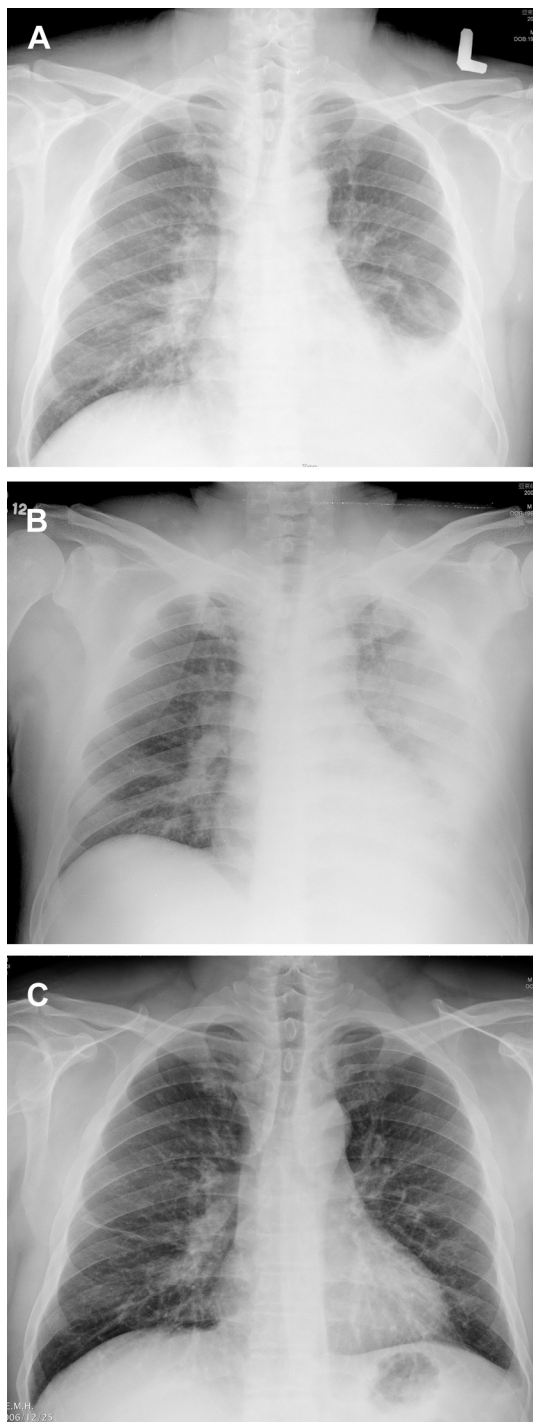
(A) Chest plain film in May 2006 shows haziness in the left lower lung field, increased infiltrates in the right lower lung field, near the right hilum, and suspicious upper mediastinal widening. (B) Chest plain film in September 2006 reveals a relapse of the left lung haziness after 7 weeks of anti-tuberculosis therapy. (C) Chest radiograph in October 2008 shows no apparent lung lesions.
